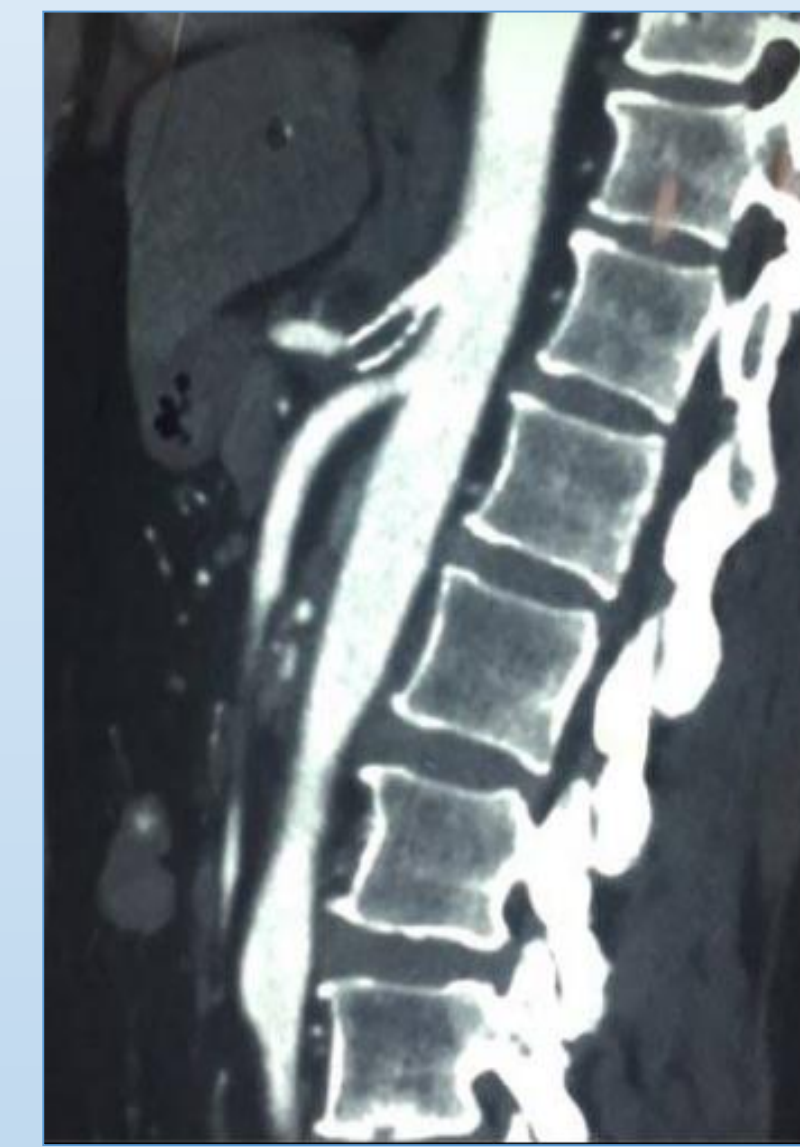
CT scan showing thrombosis of the stent
